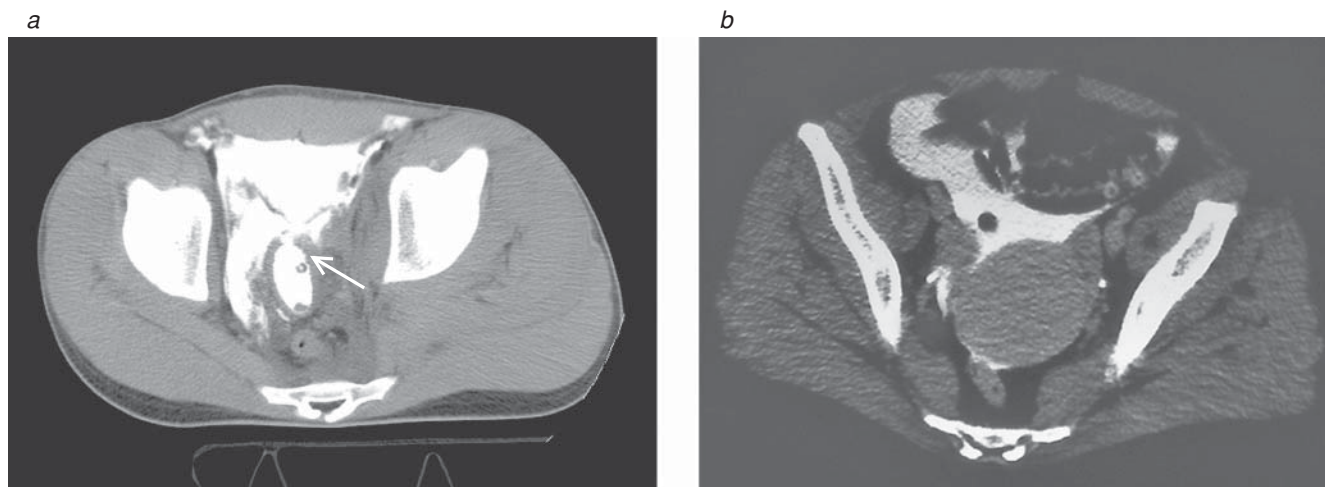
(a) Computed tomographic (CT) cystogram showing extraperitoneal bladder rupture. A definitive discontinuity in the bladder wall is visible (arrow). (b) CT cystogram showing intraperitoneal bladder rupture.
